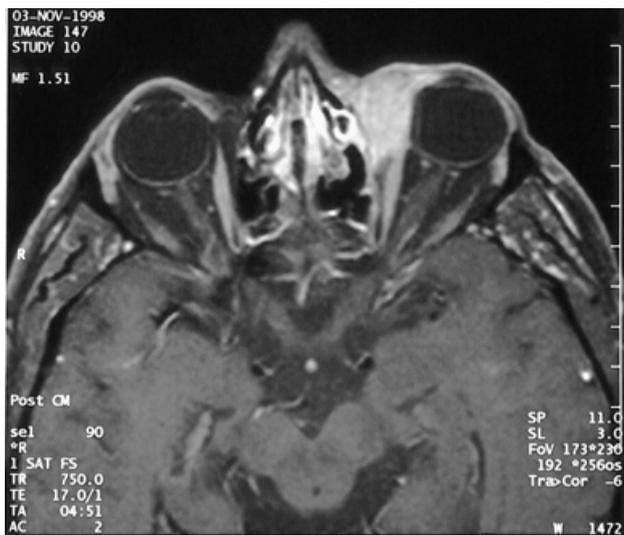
Magnetic resonance imaging scan showing an extensive deposit of metastatic cutaneous squamous cell carcinoma (SCC) displacing the left globe. This occurred secondary to perineural invasion from a previously treated forehead SCC. The patient underwent orbital exenteration and adjuvant radiotherapy.
